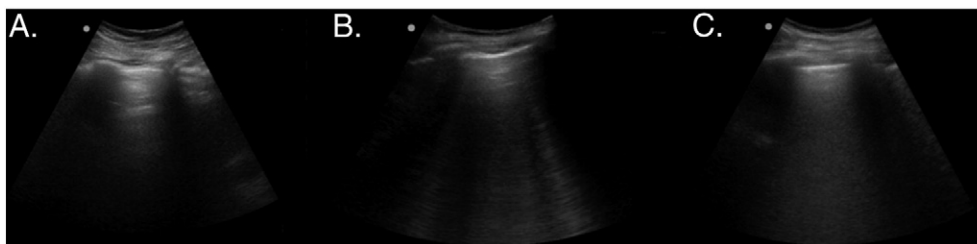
Lung ultrasound clips showing varying degrees of pulmonary edema in a single intercostal space. A, Normal lung. B-lines are absent. Horizontal lines called A-lines run parallel to the pleural line. B, Pulmonary edema. Several discrete B-lines extend from the pleural line to the bottom of the screen. C, Severe pulmonary edema. B-lines have coalesced into a single hyperechoic band extending from the pleura.
